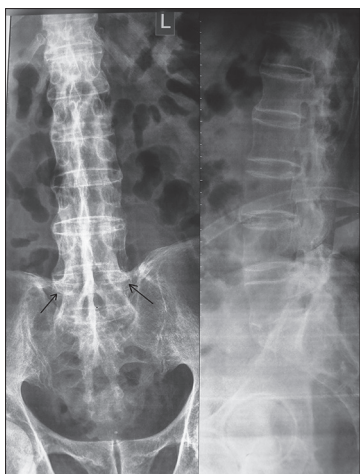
X-ray of lumbosacral spine showing bilateral sacroiliitis, calcification of anterior and posterior longitudinal ligaments with syndesmophytes and bamboo spine. Needle insertion point and direction is marked by black arrows
